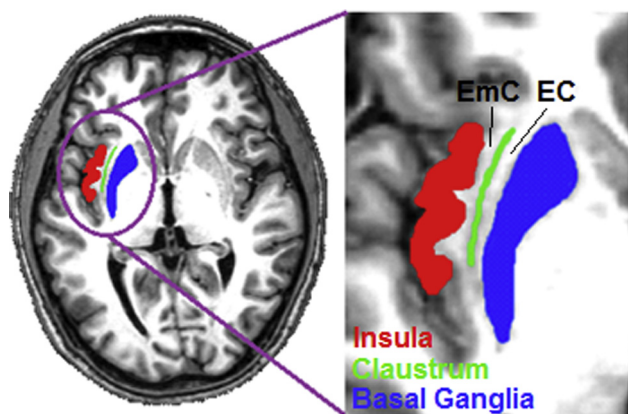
Axial MRI scan highlighting the region of the extreme capsule. Red = Insular Cortex; Green = Claustrum; Blue = Putamen. The extreme capsule (EmC) is the region of white matter that is found between the insular cortex and the claustrum. The external capsule (EC) is the region of white matter that is found between the putamen and the claustrum.
